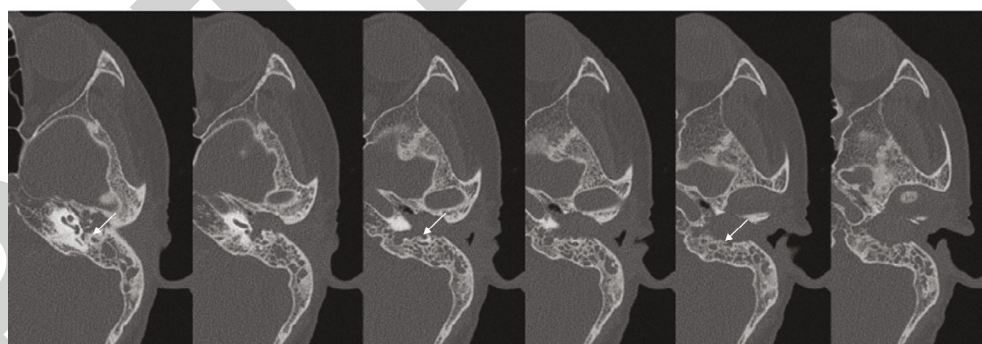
CT of EACC stage III patients (white arrow: the vertical segment of the facial nerve is destroyed and exposed).
